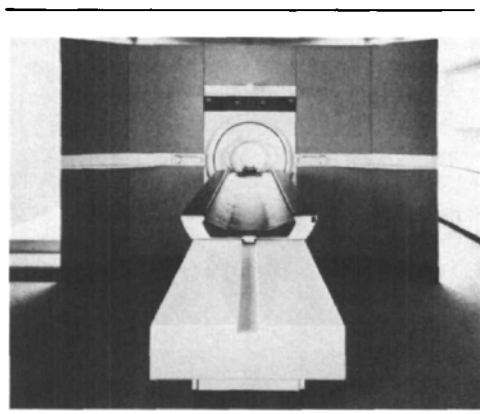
Example of an MRI installation, showing the patient feed tube and surrounding magnet enclosed in a cabinet.
